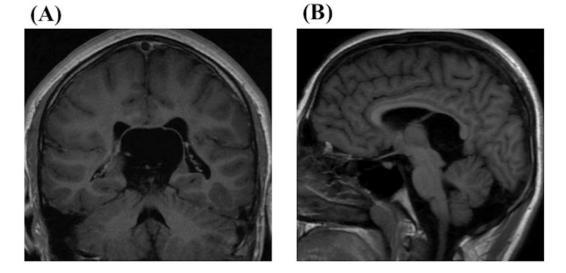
A 13-year-old boy associated with diplopia presented with a large quadrigeminal cistern arachnoid cyst on MRI (A; coronal section and B; sagittal section on T1WI). His symptom improved immediately after endoscopic fenestration between the lateral ventricle and the cyst.
